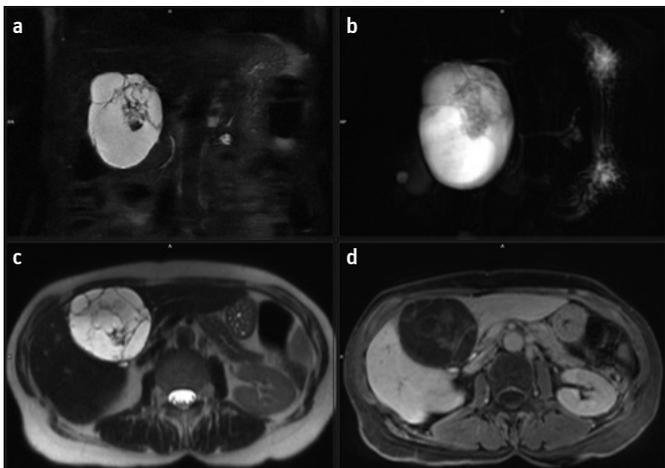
a-d. MRI of a biliary cystadenoma with T2-weighted sequences using high definition imaging (a) coronal plane, (c), (b) MRCP and (d) T1-weighted sequence after application of gadolinium contrast medium
